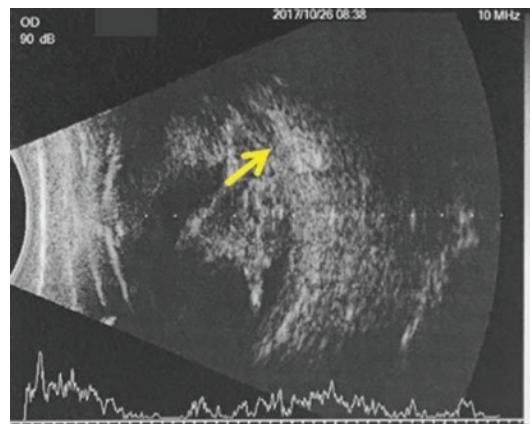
The B-scan ultrasounds of the right eye acquired 10 days after the primary surgery which show incarceration of substance with irregular shape and strong echo around the possible exit wound
